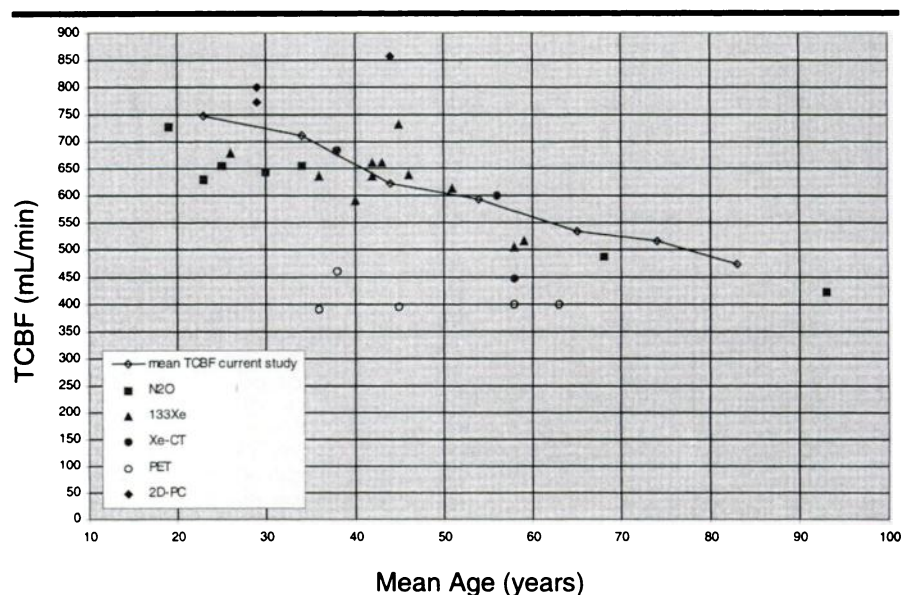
Graph shows mean total CBF (TCBF) according to age as measured in the current study and the calculated mean total CBF values according to mean age derived from previous studies in which nitrous oxide inhalation (N_2O) (21,23–25,27), Xe-133 scintigraphy (^{133}Xe) (30–38), xenon CT (Xe-CT) (39–41), PET (42–44), and 2D phase-contrast MR angiography (2D-PC) (9,12,18) were used.
